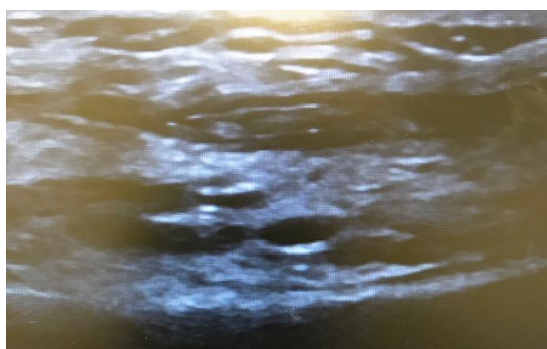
USS of lateral aspect in longitudinal plane, smaller hypoechoic collection visualised with appearances similar to previous MRI reported
